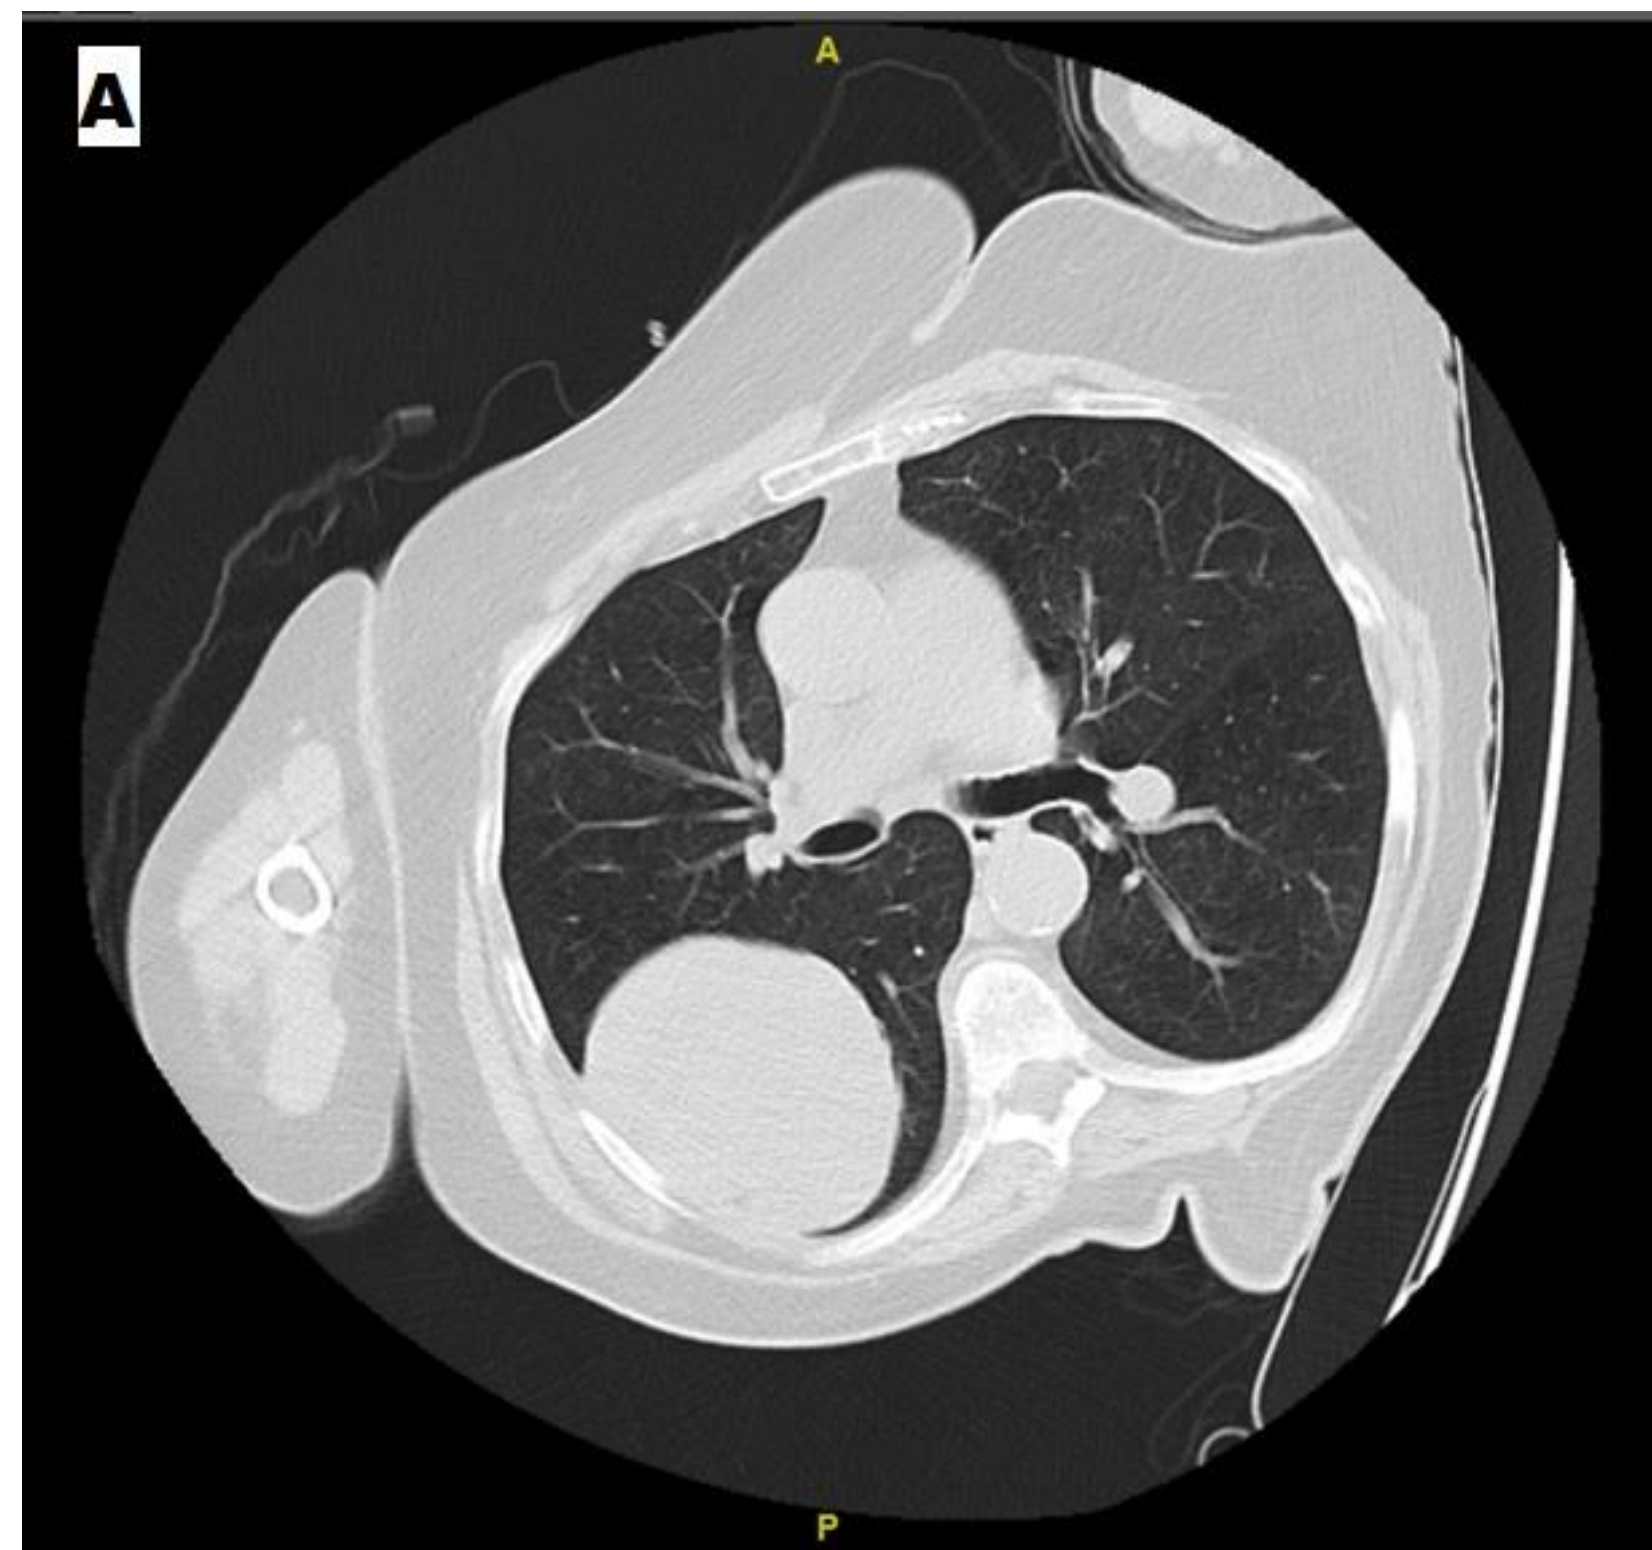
Computed tomography of the chest showing a large (8.4 x 7.8 cm) mass within the superior segment of the right lower lobe extending to the right upper lobe.
